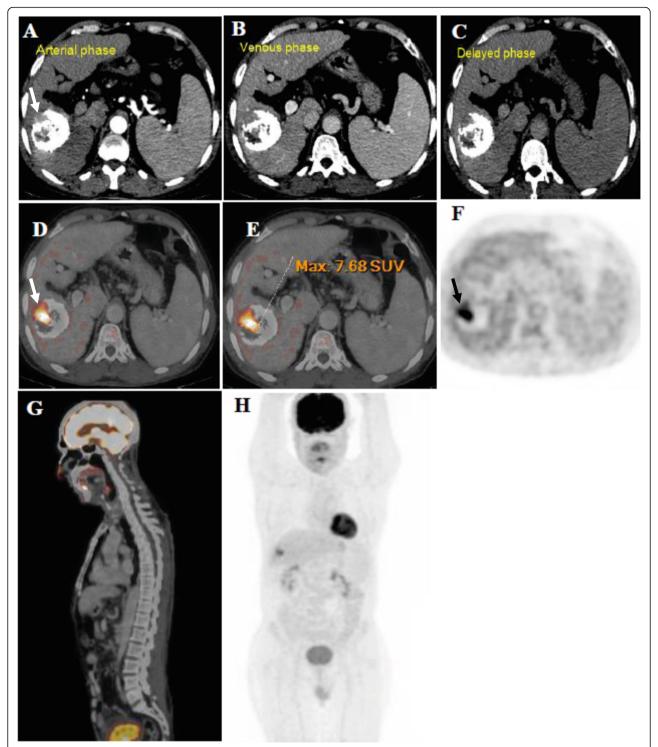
a–c CECT phases revealed localized lipiodol concentration at the right hepatic lobe chemoembolized lesion with residual area at the anterior part of the lesion with defective lipiodol and mild contrast enhancement(arrow). d and e Fused PET/CT image showing hyper metabolic activity at the suspected superior margin of the chemoembolized lesion(arrow). f Axial computed tomography-based attenuation correction image (CTAC) image showing focal FDG uptake(arrow). g Sagittal fused PET/CT whole spine shows no vertebral osseous deposits. h 3D CTAC summarizing the whole study
